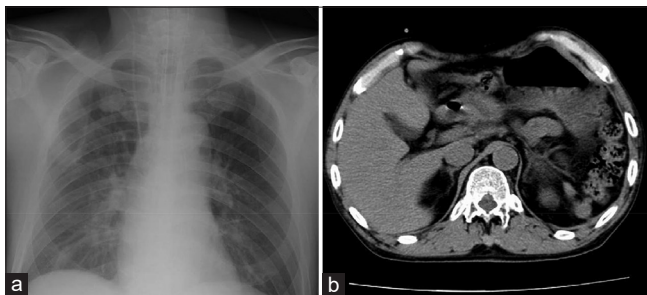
Radiographic examinations Chest X-ray (a) and computed tomography (b) after sudden deterioration on day 2 from admission. Slight pneumonia was visible in his right lung. No spleen was observed in the left abdomen
